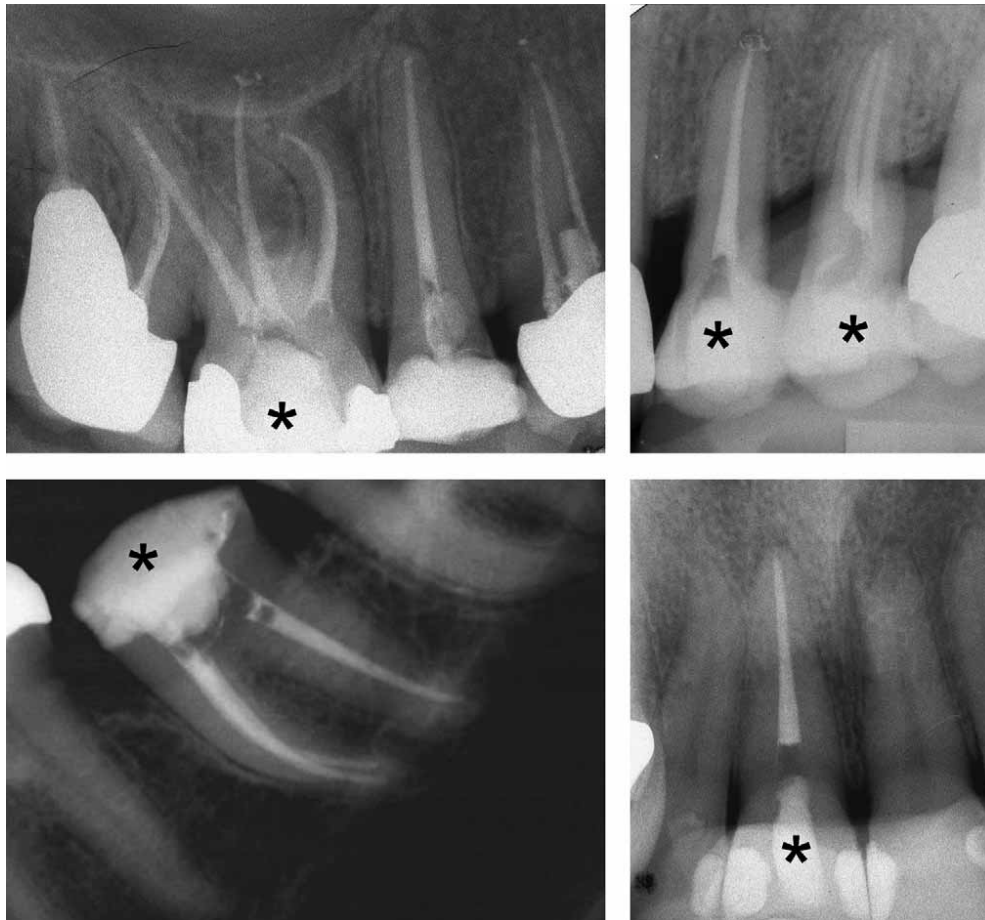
SAF in clinical use. Postoperative radiographs of clinical cases treated with the SAF file. *SAF-treated teeth.
